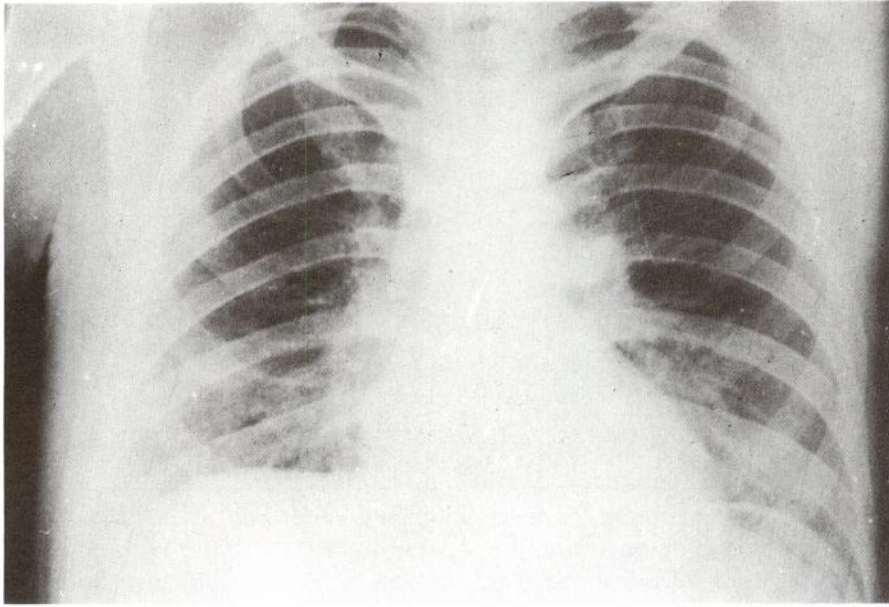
Chest radiograph of patient No. 1 showing interstitial infiltration in both lower lung fields.
